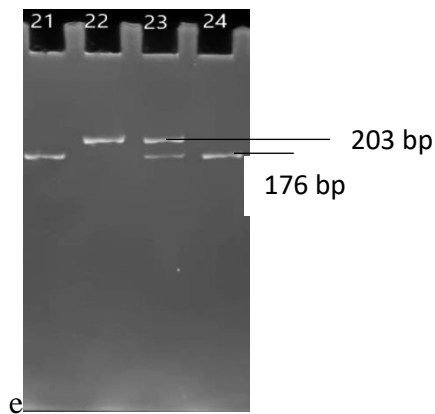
The Polymorphism of CTLA-4 CT 60 showed three types variants that can be seen in sample number 21-24.
